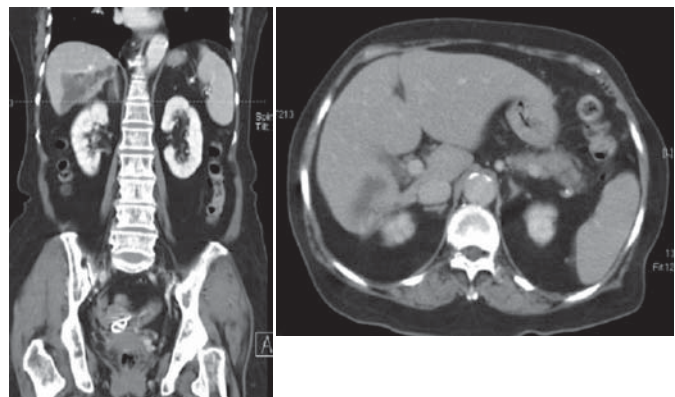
Post-contrast enhanced CT scan: A mass lesion in S6 of liver with adjacent intrahepatic duct dilatation.
